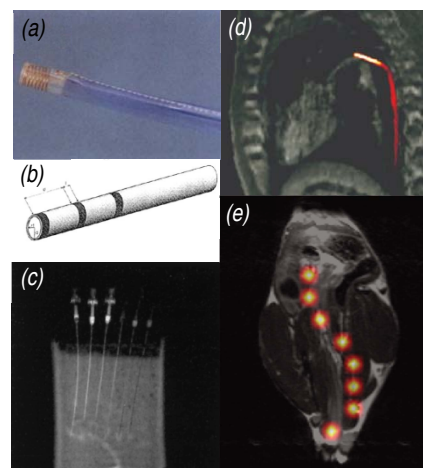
Examples of MRI-guided catheter tracking. (a) Mini rf coil (Leung, *et al.* AJR—1995); (b) Dysprosium rings (Duerk, *et al.* MAGMA—2001); (c) Gadolinium (Omary, *et al.* JVIR—2000); (d) Hyperpolarized ^{13}C -tracer (Magnusson, *et al.* Mag. Res. Med.—2007); (e) Hyperpolarized ^{29}Si particles (Whiting, Hu, *et al.*—2014).
